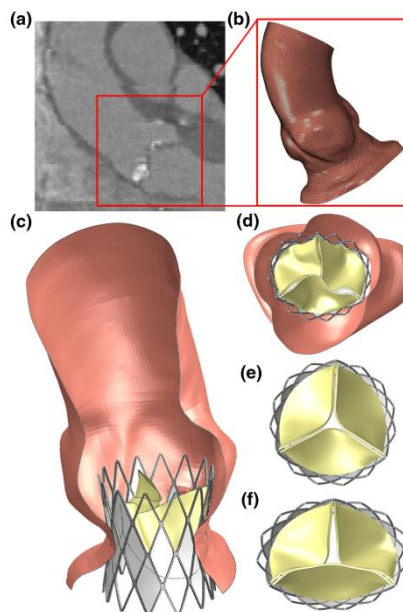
Effect of deployment geometry on TAVR leaflet deformation adapted from Gunning et al. (2014), showing (a) CT scan of aorta, (b) 3D mesh reconstruction and (c-f) TAVR deployment in several aortic root geometries.
